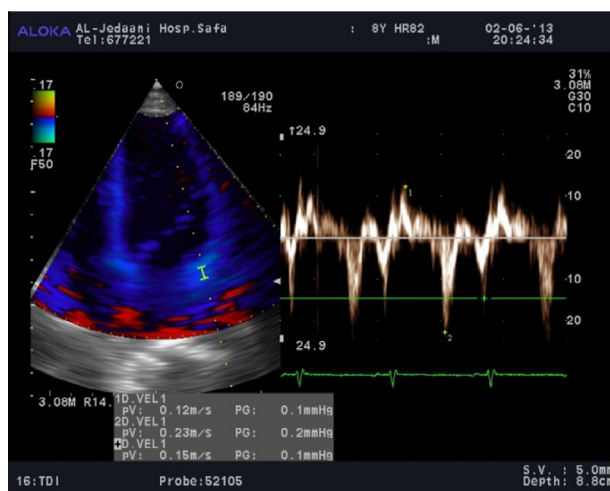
Tissue Doppler echocardiography on the lateral mitral annulus showing normal early diastolic myocardial velocity.
